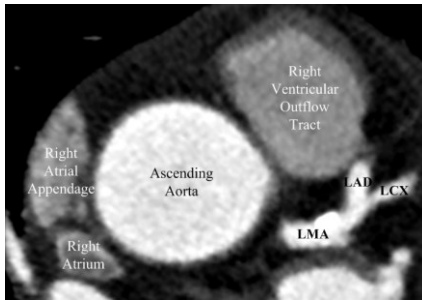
Single, transverse slice from the original CT data set. The major segmentations of the left coronary tree can be seen. LMA, left main coronary artery; LAD, left anterior descending artery; LCX, left circumflex artery.
